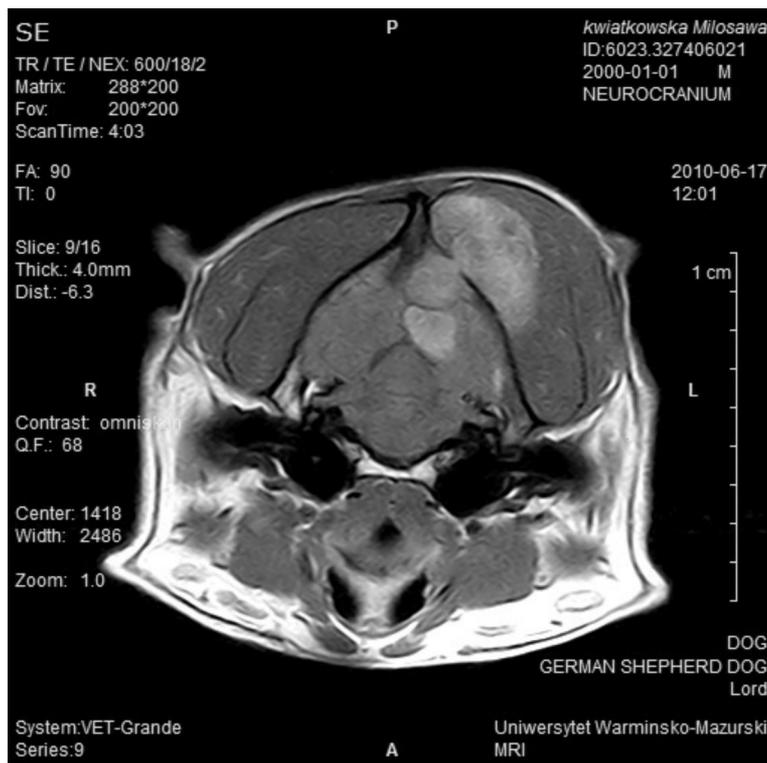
Upon MRI the masses had intense contrast enhancement on postcontrast T1-weighted SE sequence in the transverse plane.
